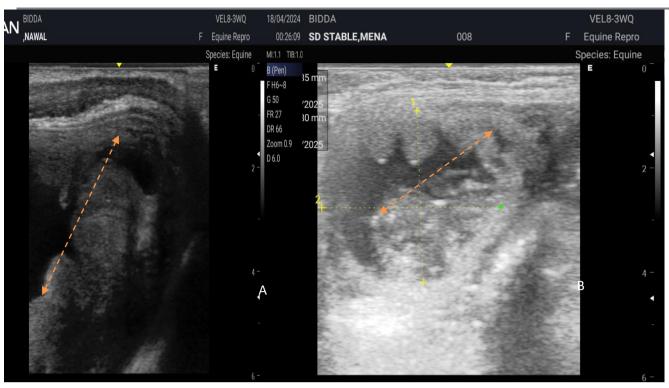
Side view of trans-rectal sonograms of a pregnant mare in its second trimester showing fetuses on ventro-sacral position (pink dotted arrow)
